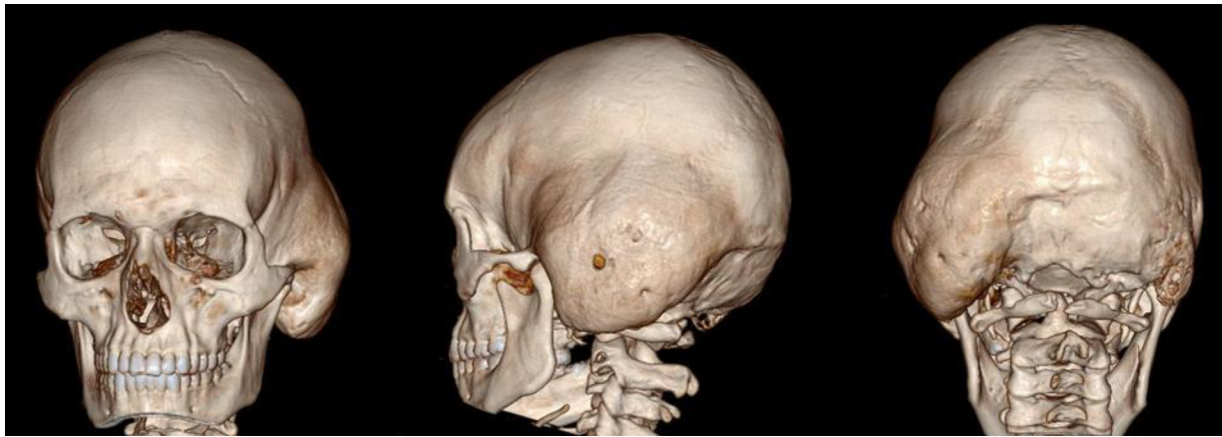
CT 3D reconstructions demonstrate enlargement of the left temporal-parieto-occipital region
